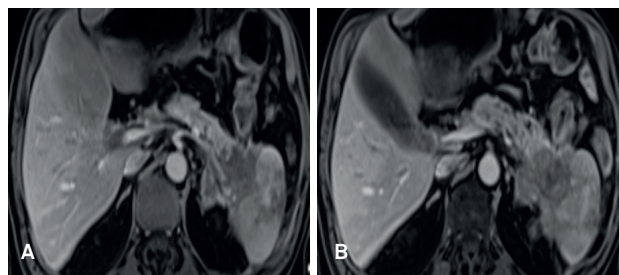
CE MRI of upper abdomen axial plane (a, b): Pancreas tail neoplasm with infiltration of spleen and liver metastases.
